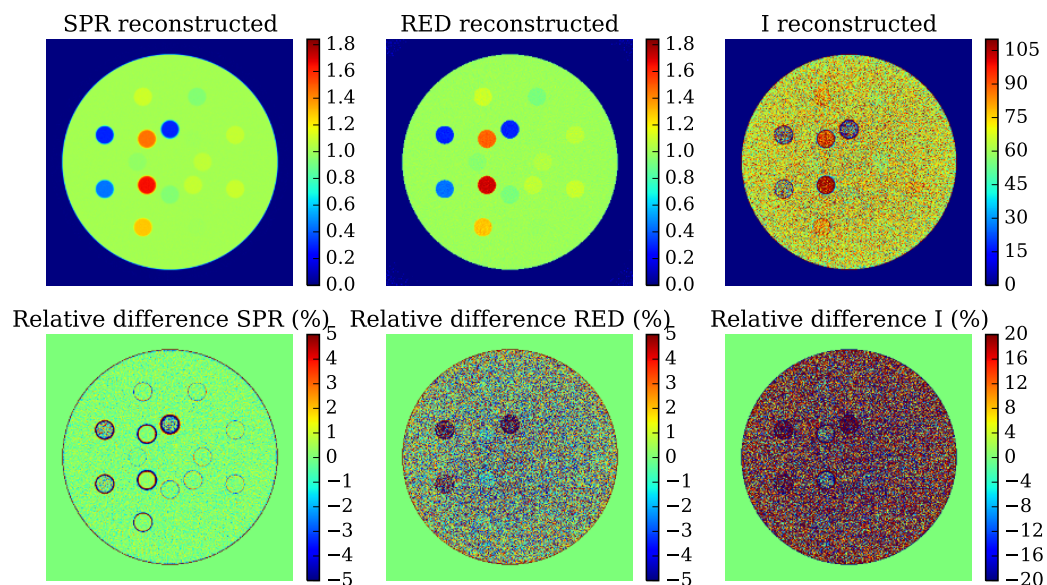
From left to right, top row: reconstructed SPR image obtained through proton CT, reconstructed RED image obtained through dual-energy CT and reconstructed I -value image determined by solving the Bethe's equation for I ; below, percentage difference maps when comparing reconstructed SPR, RED and I -value images with reference values, respectively.
